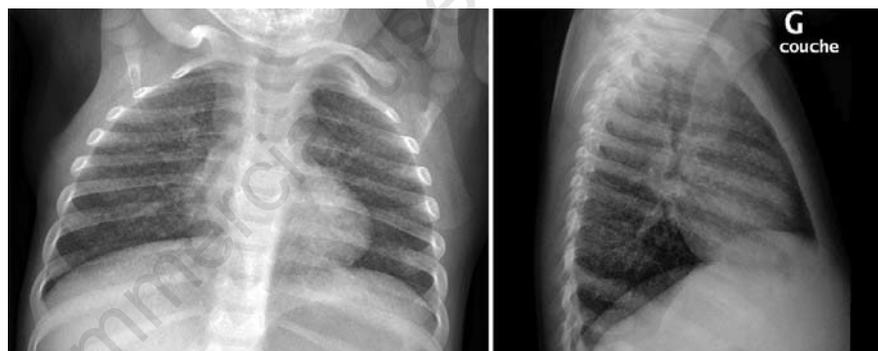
Full-face chest X-ray: bilateral micronodular parenchymal lesions. Profile: diffuse micronodular opacity including anterior mediastinum.
